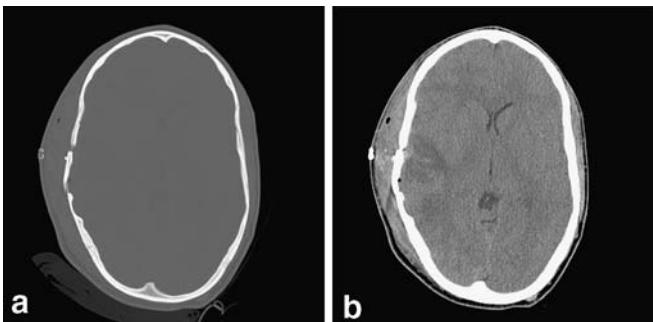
a Post-operative head CT scan (bone window) demonstrating the reconstructed skull after surgical elevation on the same patient; b post-operative head CT scan (parenchymal window) demonstrating the reconstructed skull after surgical elevation on the same patient
